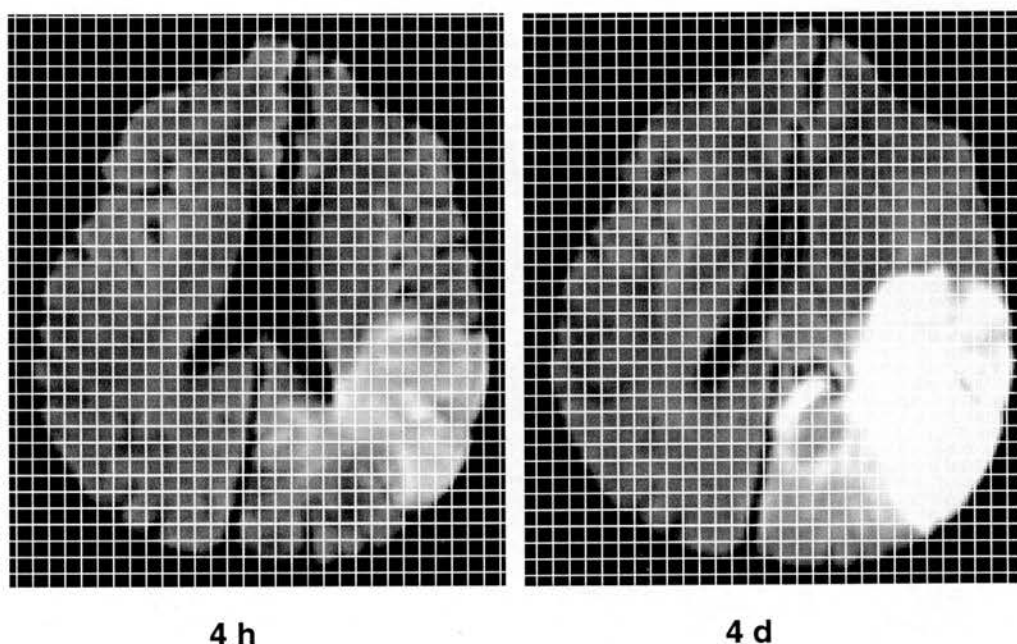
DWI at 4 hours and 4 days after stroke onset (in Patient A, with a left hemisphere ischaemic lesion) with overlaid grid as used to score the movement of the 59 anatomical landmarks. Note the swelling at 4 days with the pronounced midline shift and compression of the left lateral ventricle.
